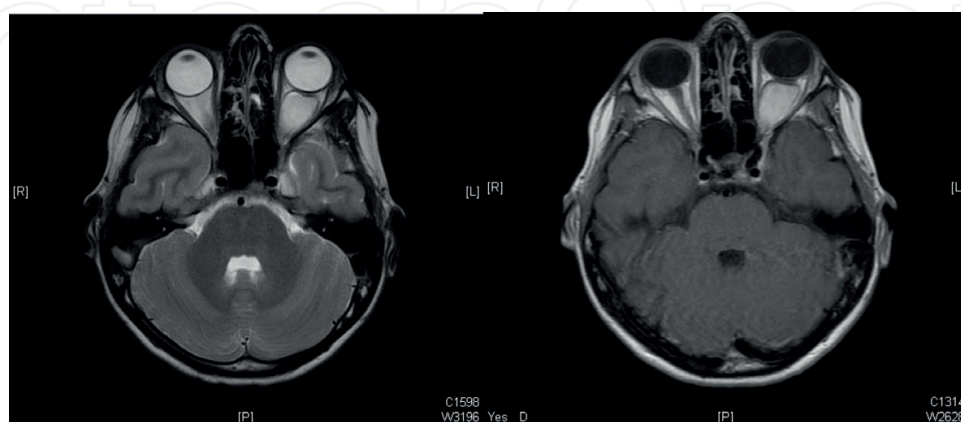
Optic nerve glioma. The left figure is a T2-weighted axial MRI showing left orbital and intraconal mass with high signal intensity. The right figure is a T1-weighted axial MRI showing postcontrast enhancement.
